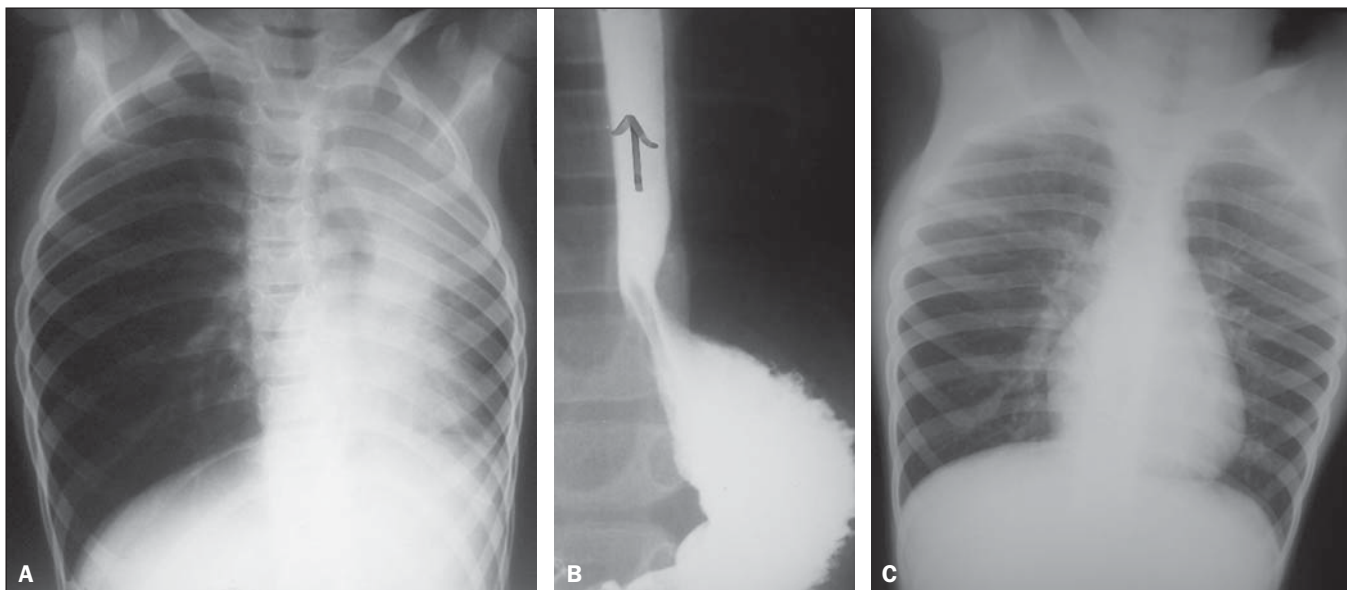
A six-year-old male child said to be asthmatic, presented with dyspnea and sudden chest pain. A: Anteroposterior view showing left hemithorax with decreased volume and transparency, right lung herniation and mediastinal displacement to the left, characterizing left lung atelectasis. B: EGDS demonstrating reflux. After four-day anti-reflux treatment, the symptoms disappeared and chest radiography was normal. C: Normal anteroposterior chest radiography after treatment for gastroesophageal reflux disease.
